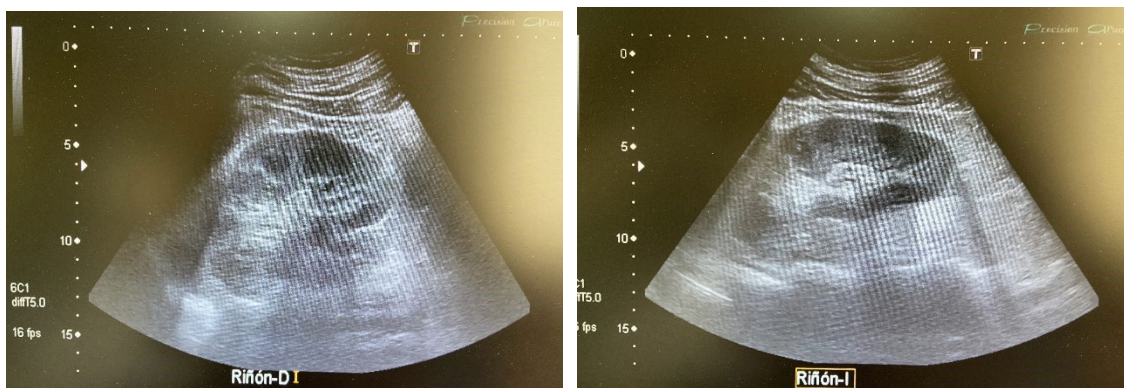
Transabdominal bilateral renal ultrasound: both kidneys in longitudinal projection without stones
